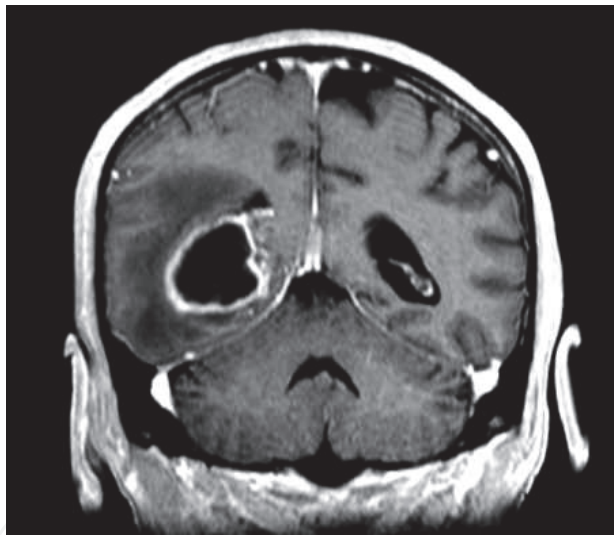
MRI, T1, peritumoral edema (From the courtesy of Dr. Consuelo Valentini, Dept. Radiology, CTO Hospital, Turin).
